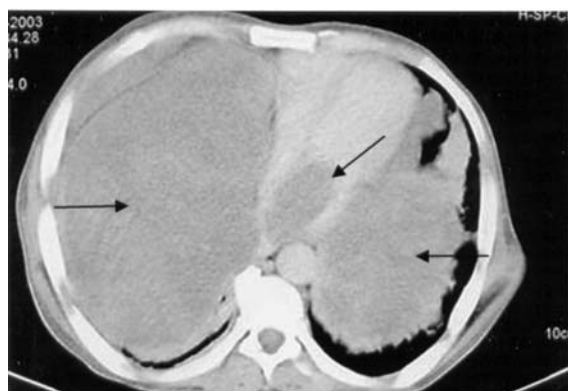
Contrast enhanced CT chest showing multiple parenchymal metastases, left pleural effusion and a filling defect in the left atrium extending across mitral valve.
